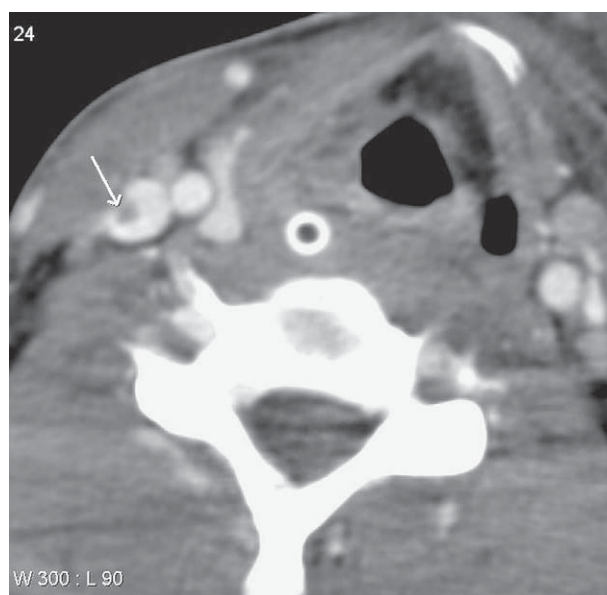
Post-contrast neck CT scan reveals a filling defect (arrow) in the lumen of the right internal jugular vein at the level of the thyroid gland, suggesting thrombus formation.
